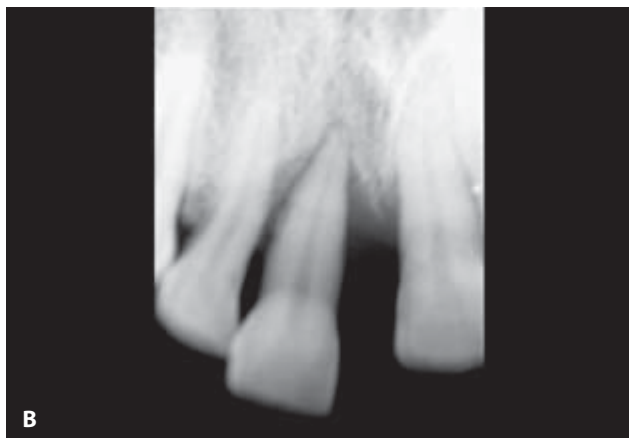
A radiographic view showing the hopeless tooth.
